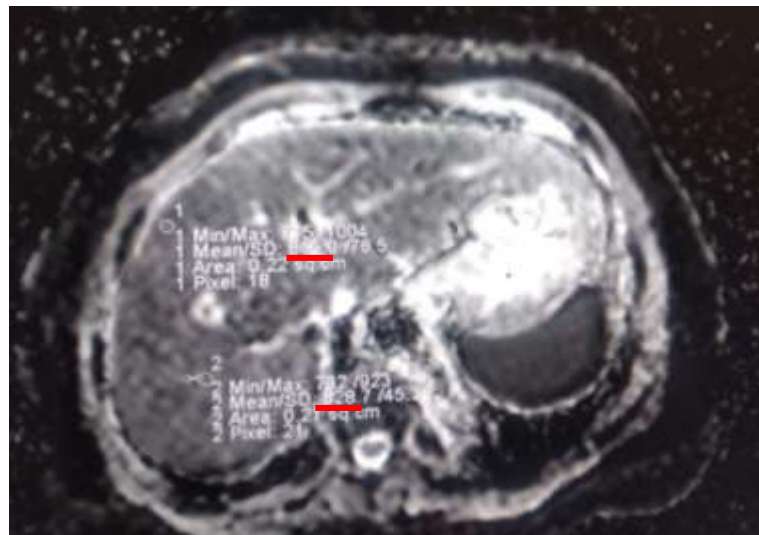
65 female patient with cirrhotic liver showing HFL on routine follow up. Dynamic MRI was done this figure showing ADC map of liver showing HFL and ROIs were applied on both HFL (ROI 2 reading 828) and on liver parenchyma (ROI 1 reading 865). ADC ratio = 0.95
